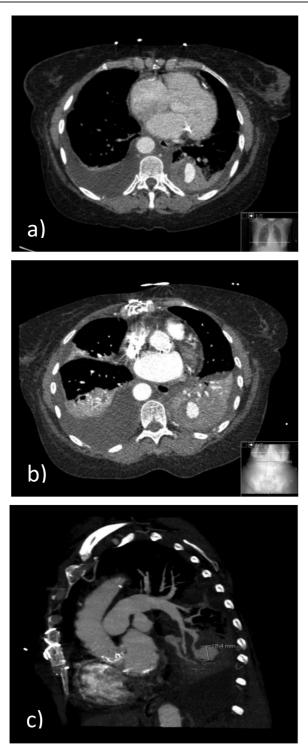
(A) Chest CT-angiography at ICU admission. consolidation at the left inferior lobe (LIL) with areas of spontaneous hyperdensity and "ground glass" opacities; Nodular lesion with contrast enhancement, at the posterior segment of the LIL, in continuity with a pulmonary artery tree branch, suggestive of a pseudoaneurysm with a mural thrombus. (B) and (C) Chest CTangiography (7th day of hospitalization). Pseudoaneurysm arising from the posterior basal branch of the left inferior lobar pulmonary artery; bilateral pleural effusion with passive atelectasis; and consolidation due to hemorrhagic alveolar filling at the LIL.
